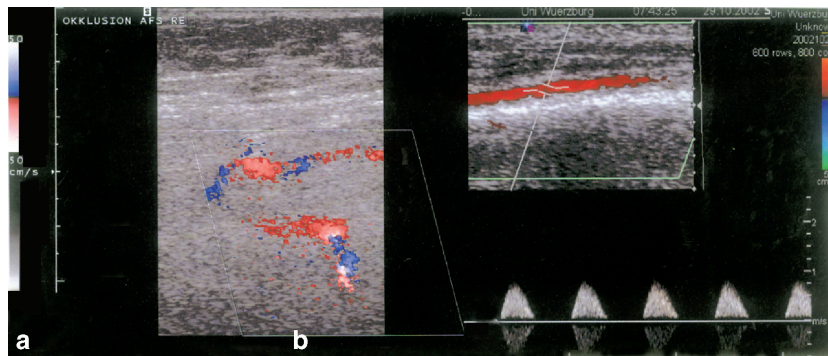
Occlusion of the superficial femoral artery. a) Collateral vessels in the color Doppler US can be traced from the original superficial artery to the popliteal artery. b) Post-occlusive spectrum in the popliteal artery with low peak systolic velocity, a broadened systolic peak and a monophasic waveform of the spectrum and low diastolic forward flow.
